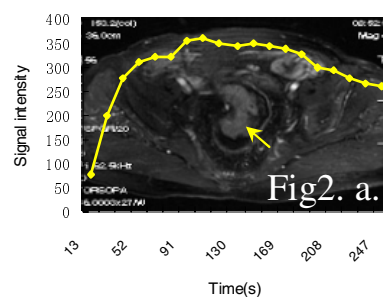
a) Arterial phase DCE-MRI shows rectal CA (arrow) with type B TIC, b) IHC with CD34 shows lower MVD and c) weak VEGF expression.
